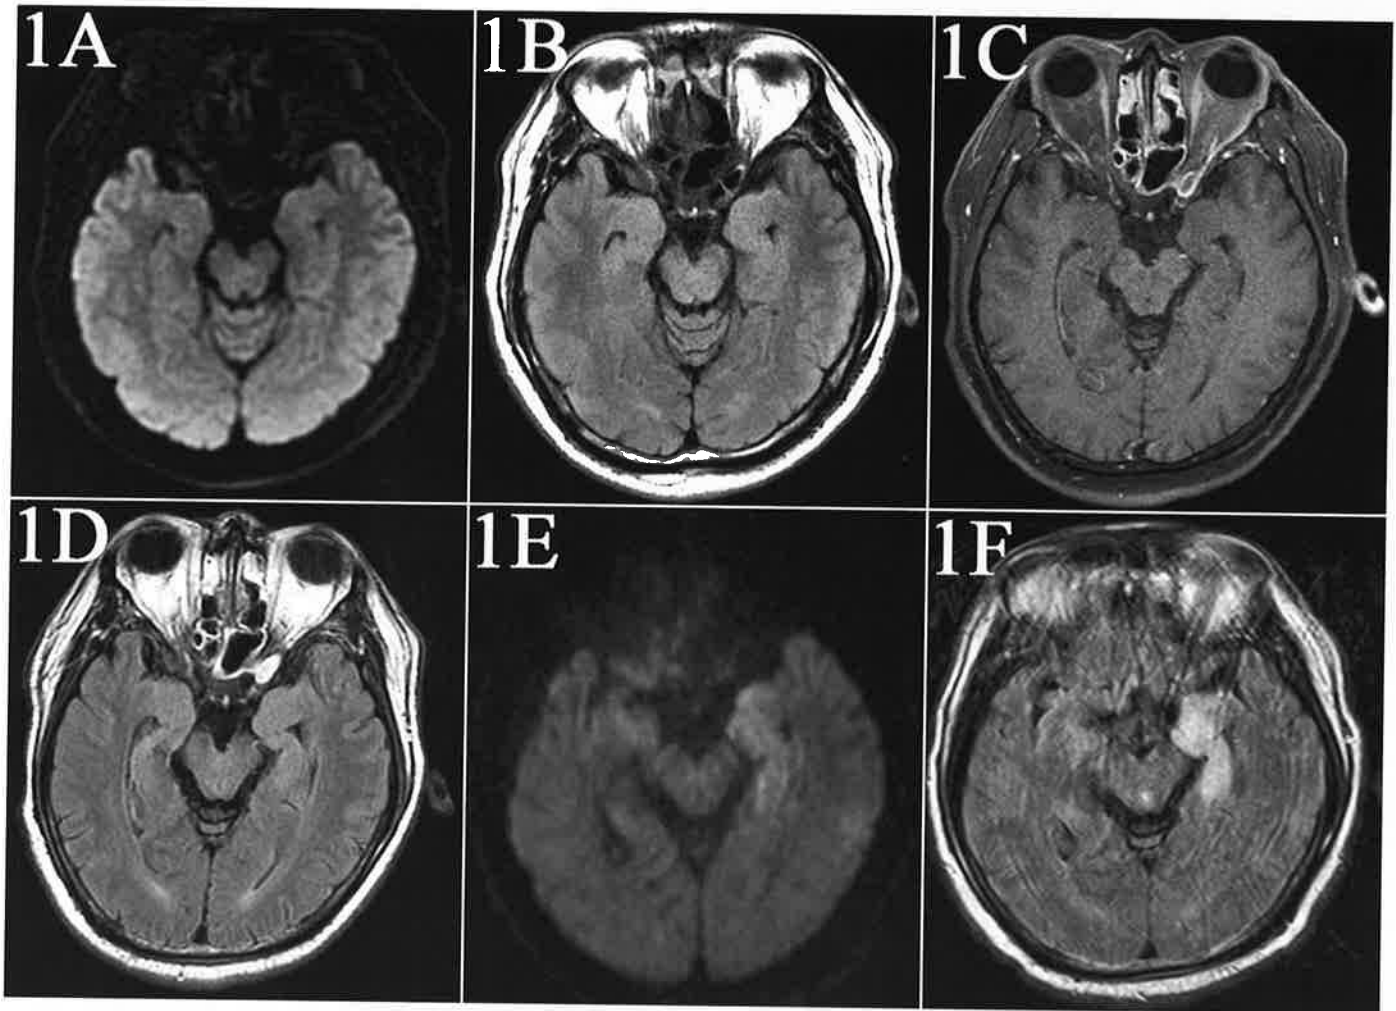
Serial cranial MRI scans of the HSE patient. On the second day following the first seizure, MRI was normal (A-Diffusion, B-FLAIR). On the 15th day, the contrasted-enhanced T1 weighted images (C) and FLAIR (D) did not reveal apparent abnormality, either. On the 23th day, abnormal signals were present on both sides of medial temporal lobe, mainly in the left hippocampus with a small lesion in the right hippocampus, which displayed hyperintensity in Diffusion (E) and FLAIR (F).
